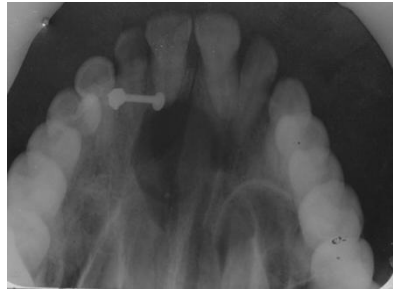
Maxillary topographic anterior occlusal radiograph showing well defined radiolucency
